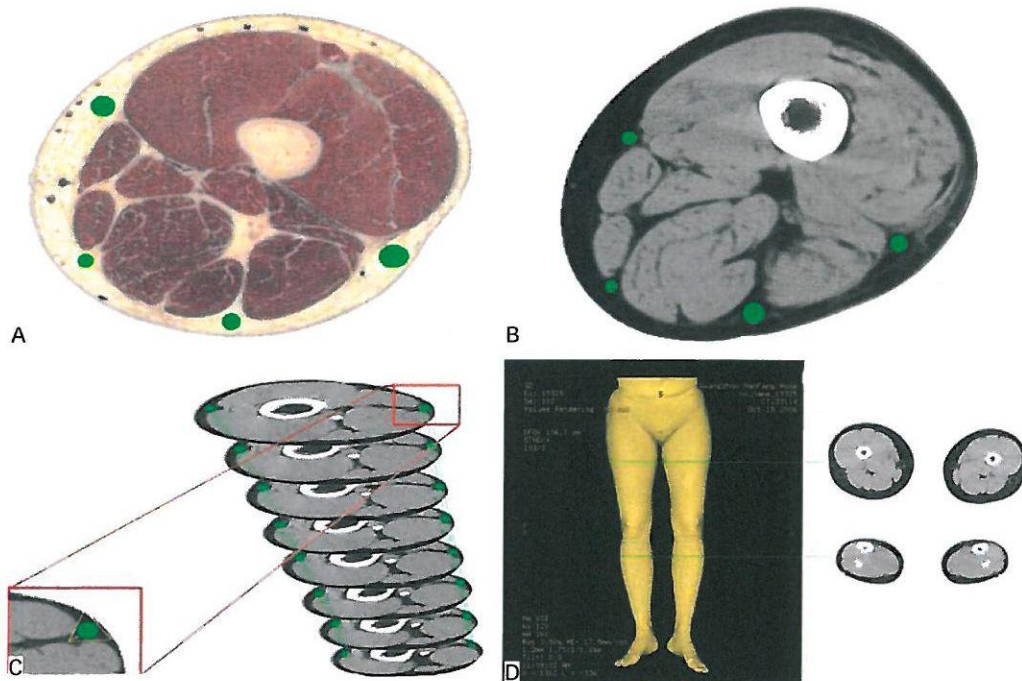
3-D reconstruction. Circles are inscribed in the connective tissues in VCH (A) and CT (B) images. The 3-D structures are then reconstructed (C and D).
